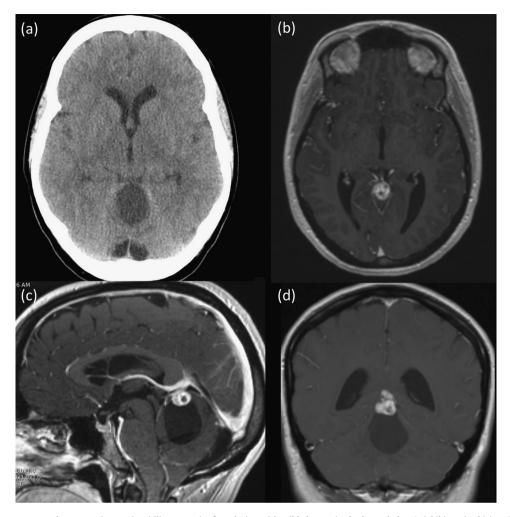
(a) Axial CT without contrast demonstrating cystic midline posterior fossa lesion with mild obstructive hydrocephalus. Axial (b), sagittal (c), and coronal (d) volumetric T1 with gadolinium MRI demonstrating enhancing lesion at the tentorial apex adjacent to the vein of galen with large cystic component with the cerebellum.
